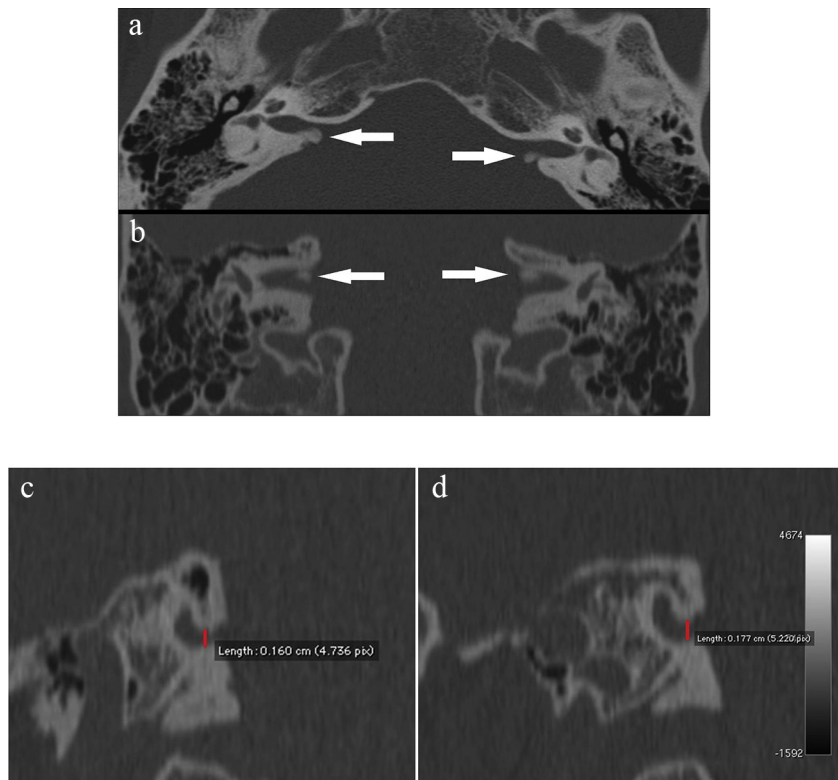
a) Axial and b) coronal CT MPR reconstruction. Bilateral asymmetric internal auditory canal osteomas, arising by the superior and posterior wall of the internal acoustic canal (white arrows). Note bilateral acoustic meatus narrowing in sagittal right (c) and left (d) reconstructions (red lines).
